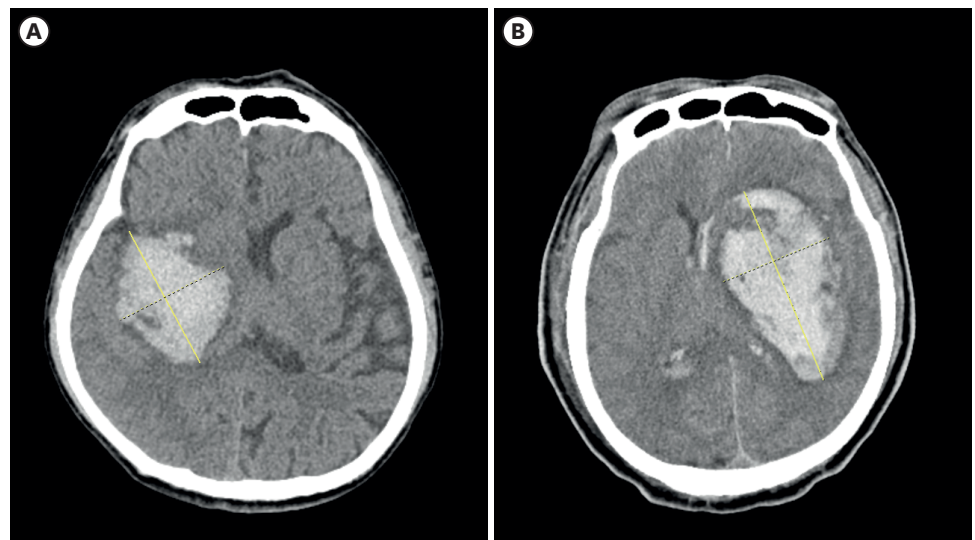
Sphericity index on CT. The sphericity index represents the ratio of the longest diameter to the diameter perpendicular to it on a CT scan. (A) A rounded hematoma, exhibiting a sphericity index close to 1. (B) Conversely, where an elliptical hematoma is present, a relatively higher sphericity index value is observed. Solid line, longest diameter; dotted line, perpendicular diameter. CT: computed tomography.
